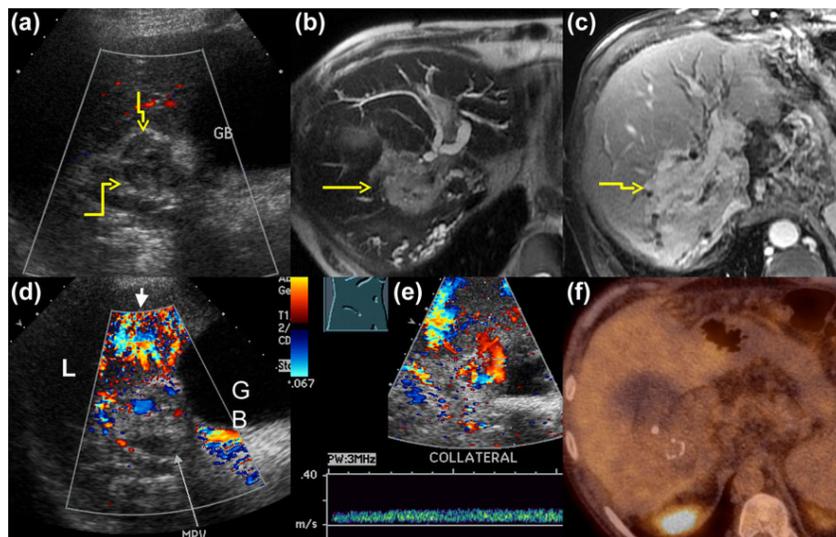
A mass (arrows) in the porta hepatis near the gallbladder (GB) was found on ultrasound (a) and MRI (b and c), showing a high T2-weighted signal (b) and a marked diffuse enhancement on post contrast T1-weighted images (c). Color Doppler imaging showed thrombus within the main portal vein (long arrow) and a highly vascular lesion (short arrow) in the porta hepatis extending toward the right hepatic lobe (d). Spectral Doppler of the collateral vessels in the porta hepatis demonstrates portal venous-type waveforms (e). The mass was not FDG-avid (f).
